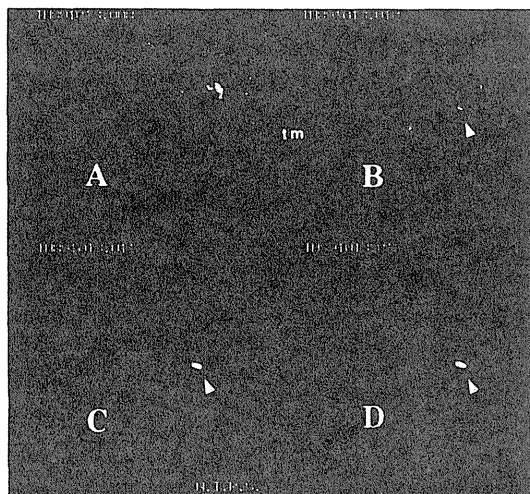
放射線増感剤 KU 2285 (50 mg, 1 ml) を左大腿に径 2 cm の NFSa 腫瘍を有する C3H マウスに腹腔内投与後、経時的に <sup>19</sup>F MRI を撮影した。投影方向は腹側→背側方向である。パルス系列は field echo 法 (繰り返し時間/エコー時間=300/10 ms)。それぞれ、投与 2 分後 (図 5-A)、12 分後 (図 5-B)、32 分後 (図 5-C)、52 分後 (図 5-D) の像である。12 分後にすでに吸収排泄された KU 2285 の膀胱よりの <sup>19</sup>F MR 信号 (矢頭) 明らかである。しかし、腫瘍 (tm) からの信号は認めない。図 5-A はマウスの腹部、下肢の輪郭を描いている。
